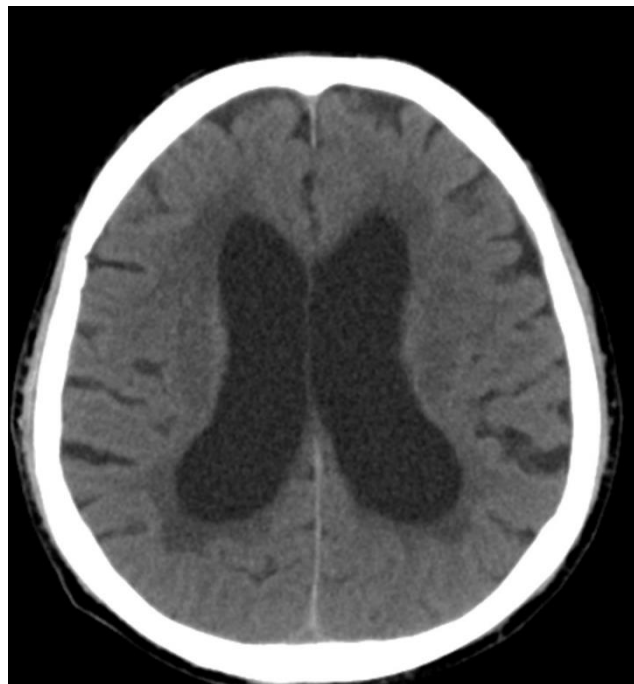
Computed tomography of head revealed the dilated ventricular system.
